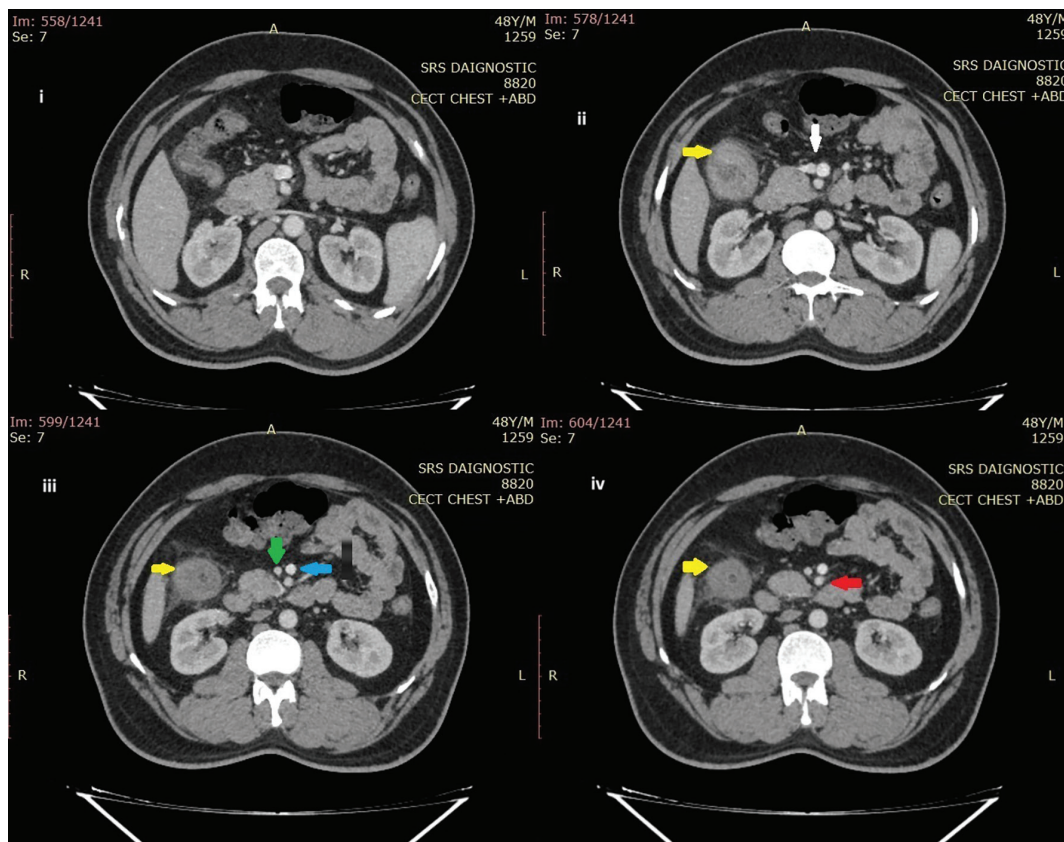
(i-iv) Sequential axial abdominal computed tomography sections showing division of the superior mesenteric vein (SMV) into two trunks and their relationship with the superior mesenteric artery (SMA). Yellow arrow: Colonic mass at hepatic flexure. White arrow: Bifurcation of the SMV into right and left trunks. Light green arrow: Right branch of SMV. Light blue arrow: Left branch of SMV. Red arrow: SMA running between and posterior to the right and left SMVs
